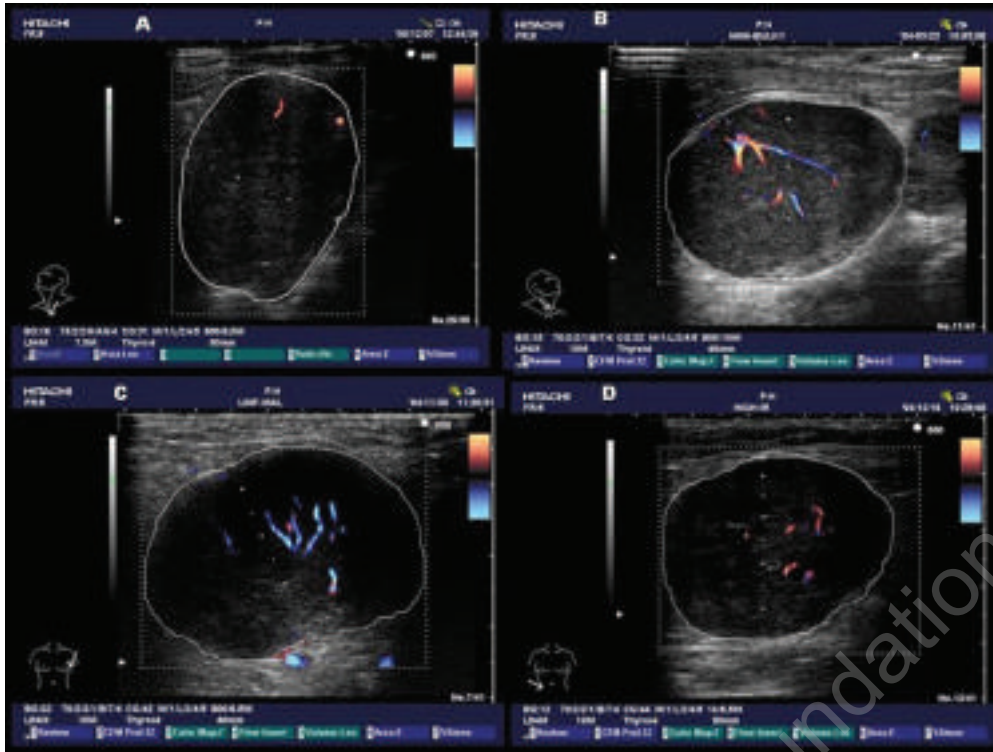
Power Doppler ultrasound (US) features. Peripheral type (A), mixed type (B), chaotic type (C), and central type (D) vasculization in bulky lymph nodes (volume ≥ 30 mL) as revealed by power Doppler US scanning in patients with Hodgkin's lymphoma.
